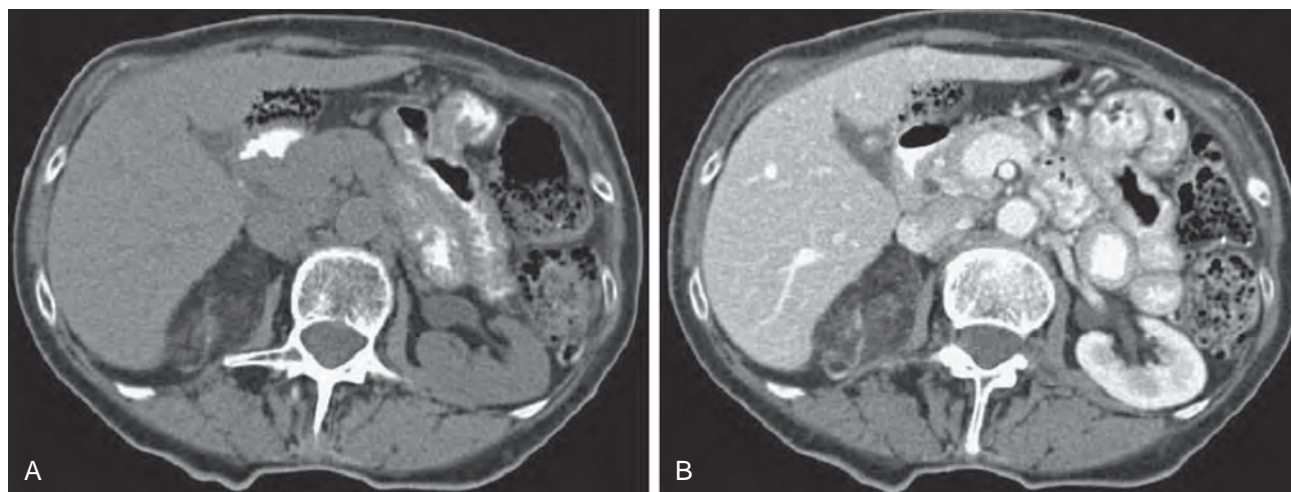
Precontrast (A) and postcontrast (B) axial cuts of a computed tomography scan demonstrating a right 6-cm × 3.5-cm adrenal myelolipoma in a 76-year-old, otherwise asymptomatic woman. (Courtesy Dr. Rosalia Viterbo, Fox Chase Cancer Center, Philadelphia.)
